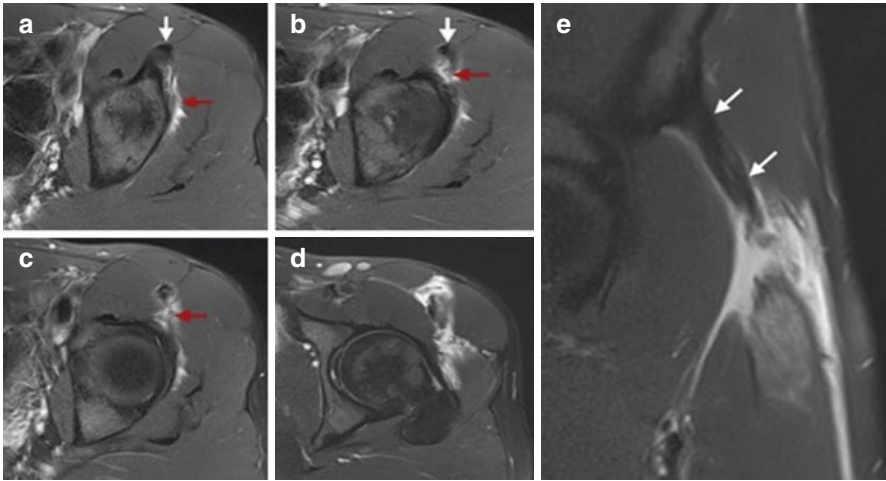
A 25-year-old woman with sudden onset of hip pain that occurred while sprinting. T2-weighted MR images with fat saturation in (a–d) axial cuts show fluid collection around the direct (white arrows) and indirect (red arrows) heads of rectus femoris which is observed in severe injuries. (e) Coronal plane shows complete rupture (white arrow) of the rectus femoris. (Reprinted by the permission of Springer Berlin Heidelberg, *Imaging of rectus femoris proximal tendinopathies*, Pesquer, L., Poussange, N., Sonnery-Cottet, B. et al. *Skeletal Radiol* (2016) 45: 889. <https://doi.org/10.1007/s00256-016-2345-3>)
